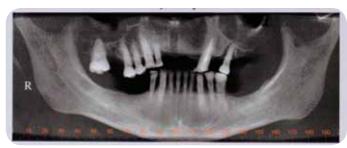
The radiograph on initial examination.
